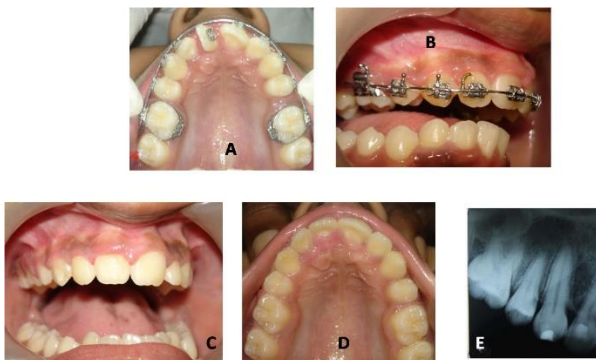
A Photograph taken during treatment. The impacted '13' has been aligned and '12' derotated. B- Photograph taken after aligning all teeth. Fibrotomy of '11' & '12' was done at this stage. C & D - Post treatment photographs taken two years after removal of fixed orthodontic appliance. E- Post treatment periapical X-ray taken two years after appliance removal.
